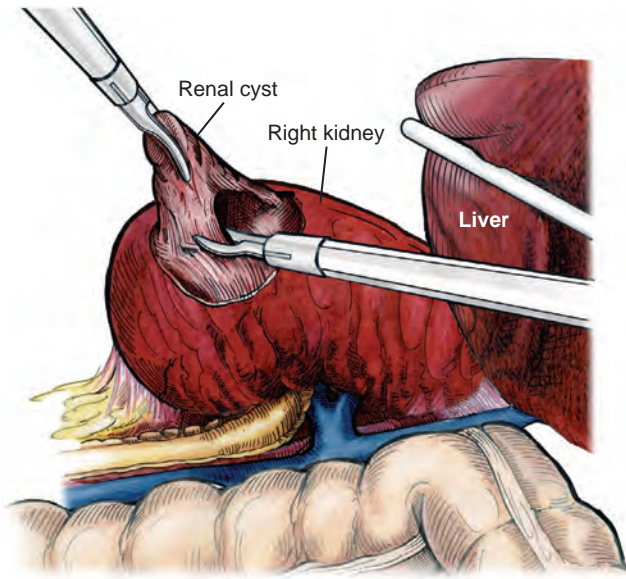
The cyst fluid is aspirated with a laparoscopic aspiration needle. After decompression of the cyst, the wall can easily be grasped and manipulated. The cyst is elevated with a grasper and scissors or ultrasonic shears to circumferentially excise the cyst wall. The edge of the cyst is carefully inspected, and biopsies are performed using the 5-mm laparoscopic biopsy forceps as needed.
